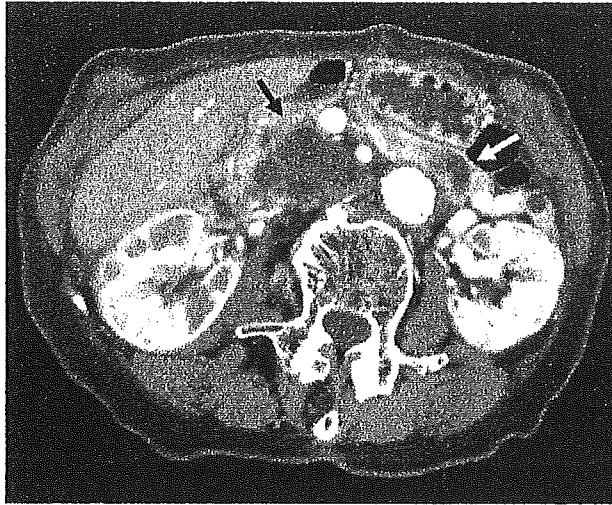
Computed tomogram demonstrating a multilocular cystic lesion in the head of the pancreas (black arrow) and a unilocular cyst in the tail (white arrow), representing multiple branch duct IPMNs.
